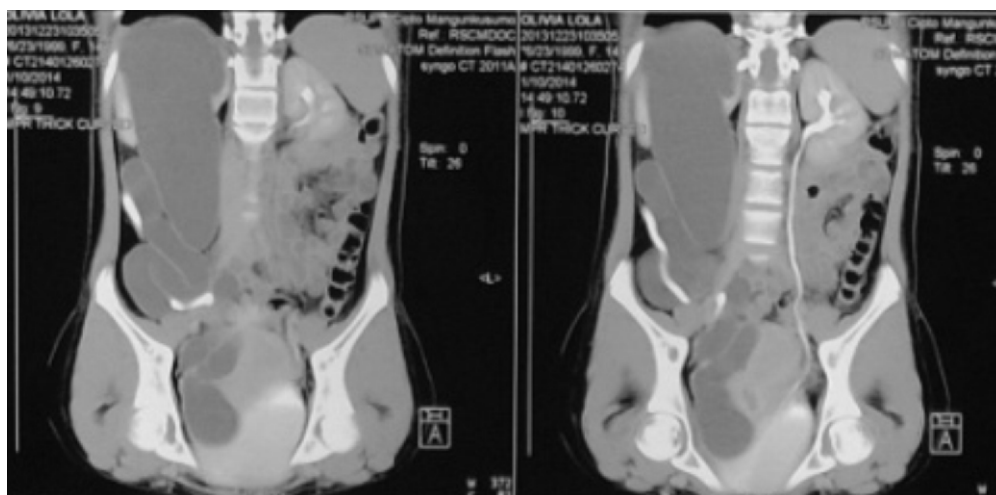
CT urography showed double collecting system of right renal with upper moiety ectopic ureter which ends in vagina.
